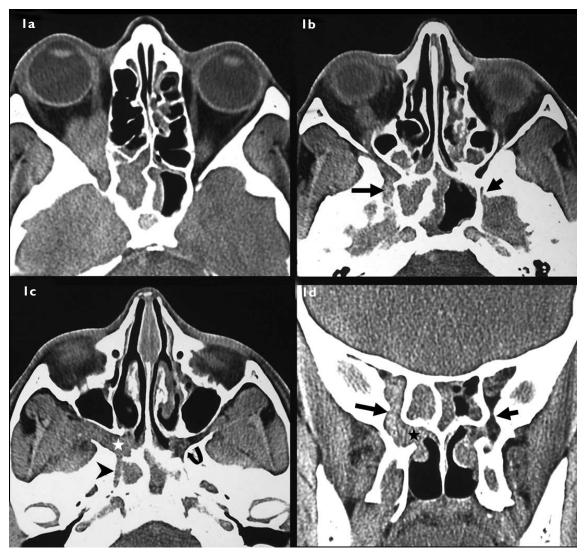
I (a) Unenhanced axial CT image shows a heterogeneous lesion with hyperdense areas in the right posterior ethmoid and sphenoid sinus that is extending into the orbit. At a more caudal level (b,c), soft tissue extension is seen within the foramen rotundum (long arrow in Fig. 1b), pterygopalatine fossa (star in Fig. 1c) and in the vidian canal (arrowhead in Fig. 1c). The involved foramina are widened compared to the normal side (foramen rotundum: short arrow in Fig. 1b, pterygopalatine fossa: curved arrow Fig. 1c). (d) Unenhanced coronal CT image taken at the level of the orbital apex shows contiguous extension of the lesion via the inferior orbital fissure (long arrow) into the pterygopalatine fossa and the sphenopalatine foramen (star). The right inferior orbital fissure (long arrow) is widened compared to the left side (short arrow).
